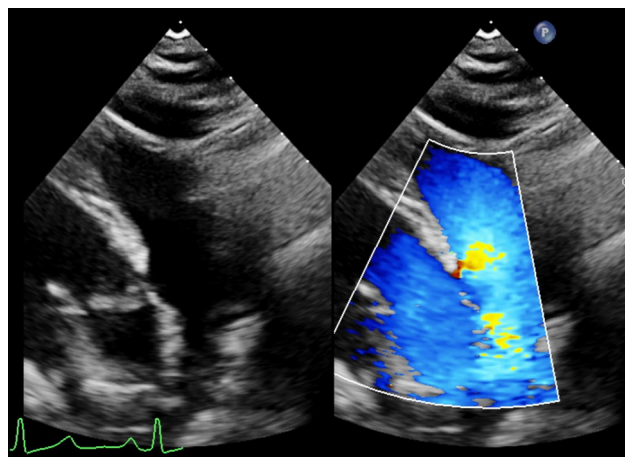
Suprasternal view with colour comparison showing the abnormal colour Doppler jet arising from the aortic arch.
